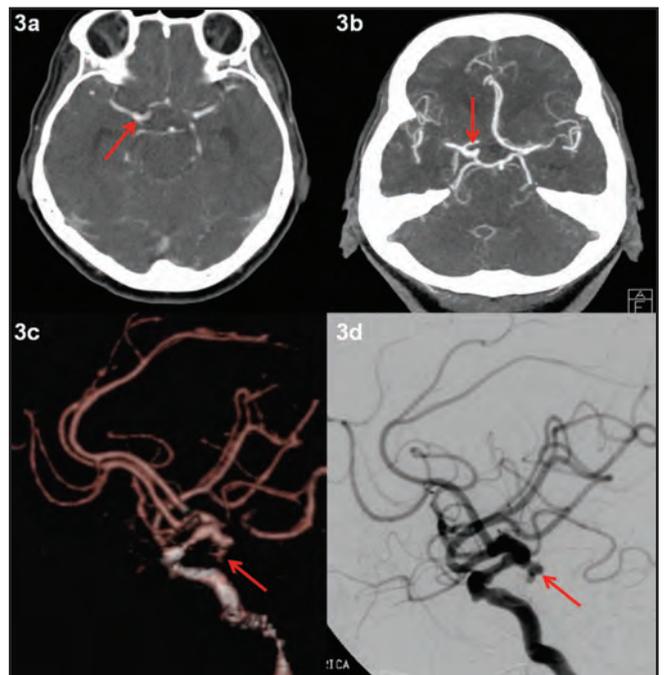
Axial CTA and MIP images, respectively, show right PCOM aneurysm (arrows) which is more conspicuous on the latter image. The aneurysm was initially missed by the registrar on-call, without the benefit of VRT and MIP images.
